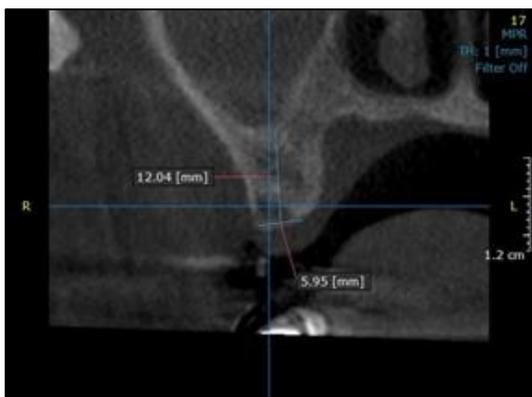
CBCT section of 17
